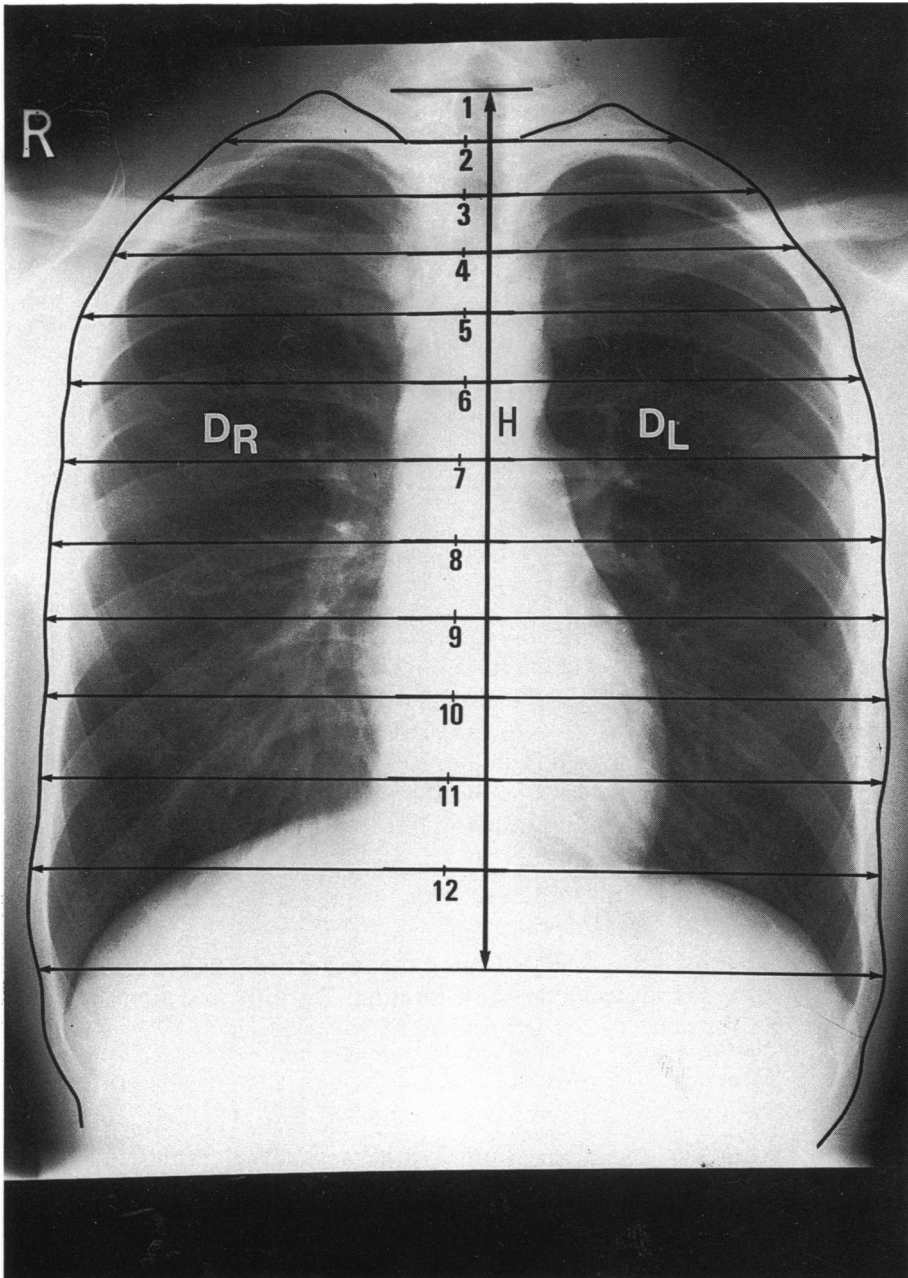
Chest radiograph to show the method of measurement for calculation of thoracic ratios. D_R (D_L) = distance measured from midpoint of the distal end-plate of each vertebral body (T1–12) to the outline of the lateral border of the right (left) thoracic cage. H, distance from T1–12 (see text).
